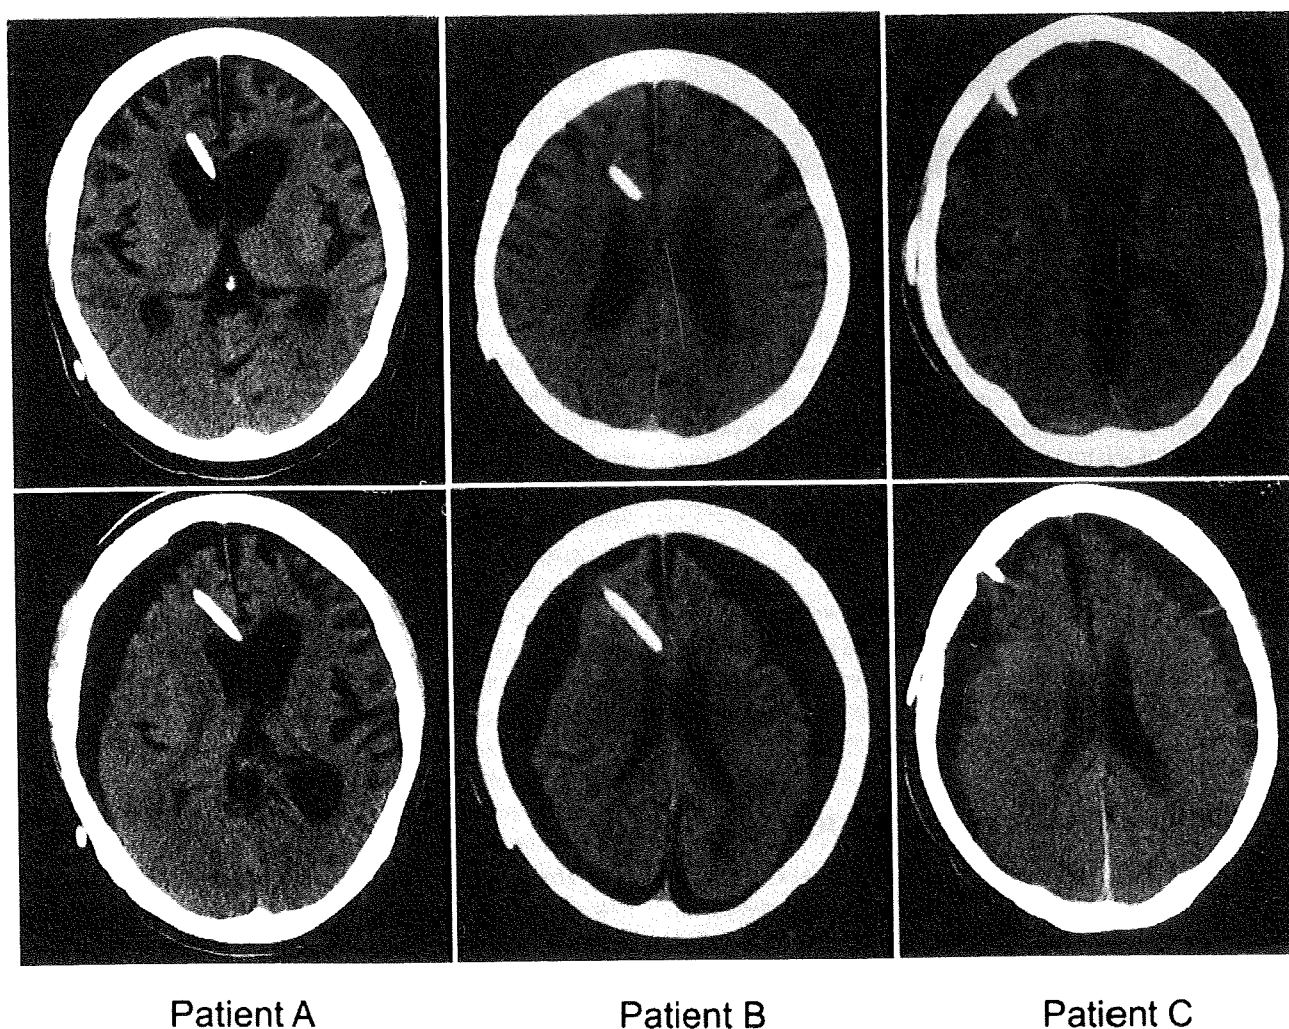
Non-enhanced serial CT scans of three patients with treatment of pentosan polysulfate (PPS) administration. Upper panels show CT scans at start of PPS administration. Lower panels show CT scan of each patient at 4 months (patient A), 5 months (patient B), and 8 months (patient C) after the start of PPS administration. Note that subdural fluid collections over one or both hemispheres are observed on all lower panel CT scans.
